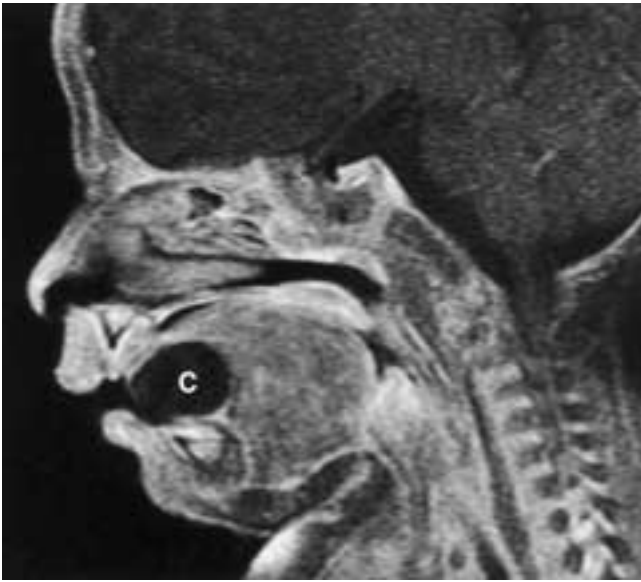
Primitive foregut cyst in a baby with a congenital tongue mass. Midline contrast-enhanced, fat-suppressed sagittal T1-weighted image shows a rounded, unilocular, sharply circumscribed cyst (c) located within the anterior third of the tongue. Note that the lesion is indistinguishable from the dermoid cyst shown in Figure 29-37.
